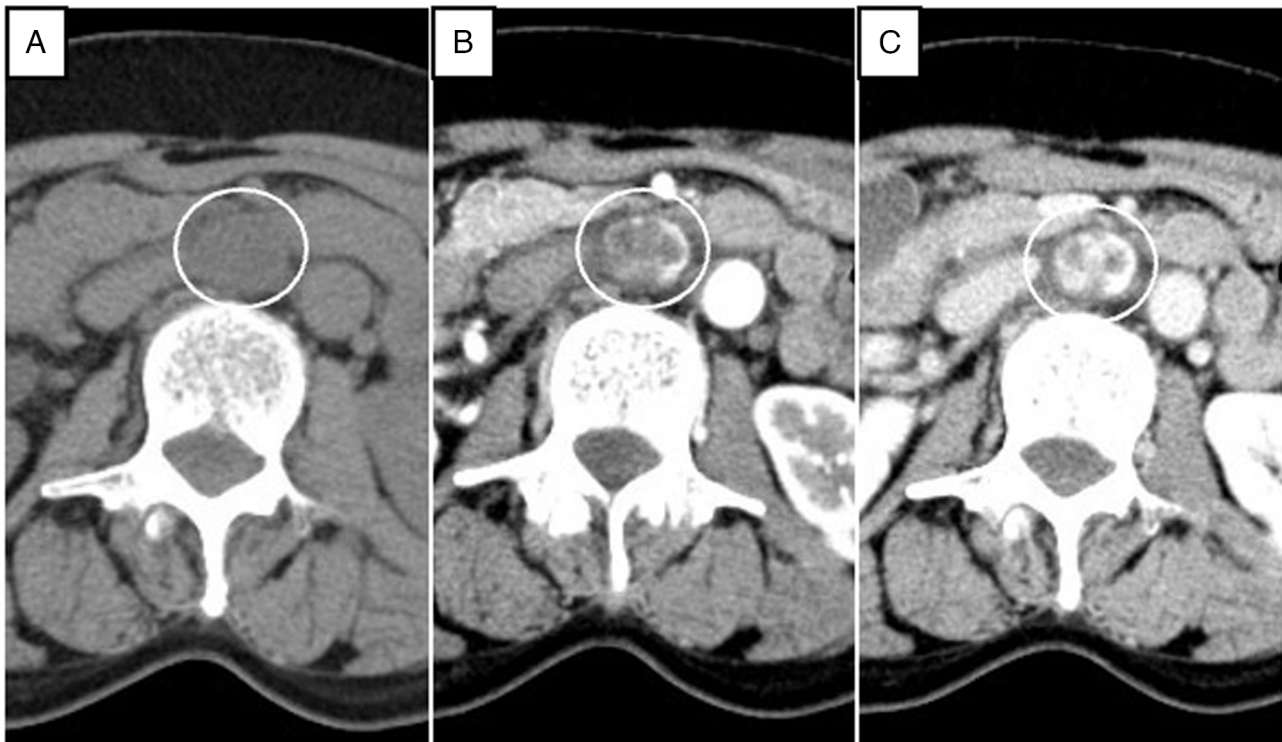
First abdominal CT scan. The white circle indicates the retroperitoneal tumor. (A) Non-contrast-enhanced CT scan. (B) Contrast-enhanced CT scan in the arterial phase. (C) Contrast-enhanced CT scan in the portal phase. The tumor showed lobulated and persistent enhancement. The size of the tumor was ~32 mm.
